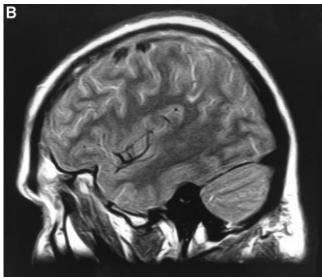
MRI axial (A) and sagittal (B) sections of H.P.'s brain showing the left subangular ischaemia.
